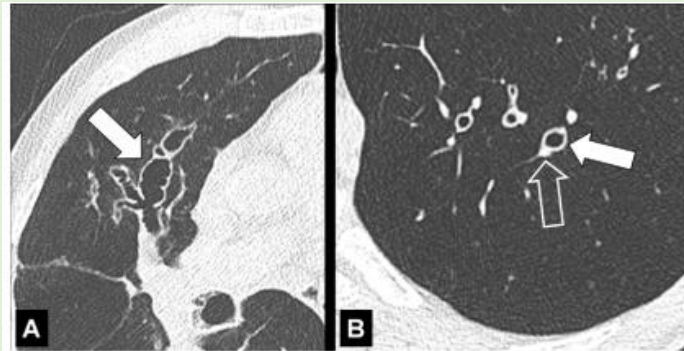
Bronchiectasis: Transverse CT images of the lungs in two different patients show severe bronchiectasis (solid arrow) in (A) right upper lobe and milder bronchiectasis (solid arrow) in (B) left lower lobe. Note the smaller diameter of the accompanying pulmonary artery (signet ring sign) (open arrow).
